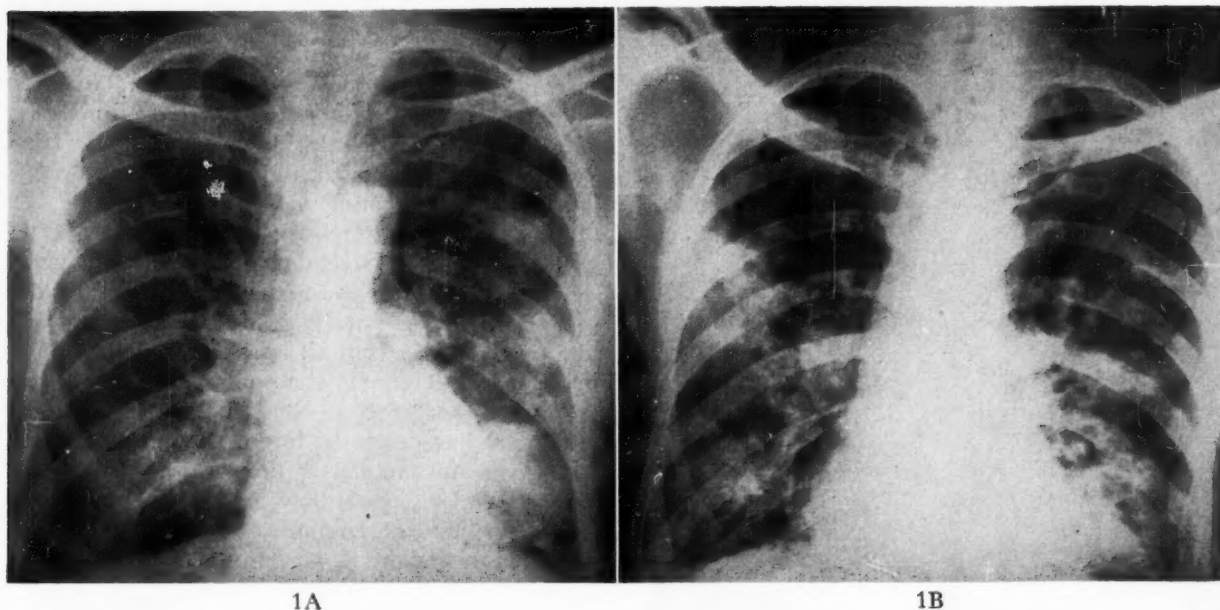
A, chest x-ray taken on November 28, 1952 showing pneumonitis involving primarily the left lung; B, chest x-ray taken on December 23, 1952 showing pneumonitis involving both lower lung fields.
